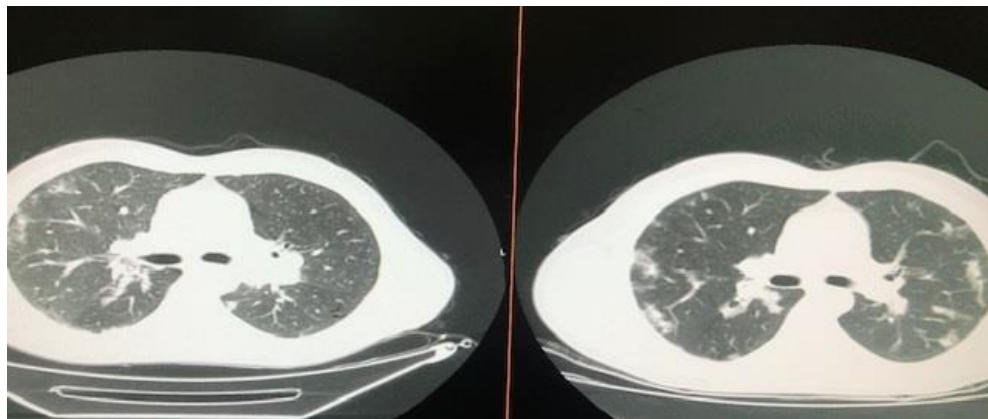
Serial chest CT shows gradual resolution of ground glass opacities, but newly developed mediastinal lymphadenopathy
